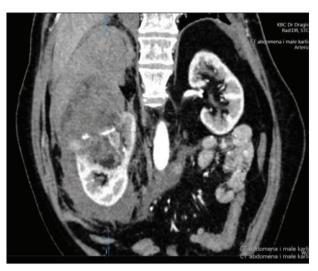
An intravenous-contrast-enhanced coronal computed tomography image shows perirenal hematoma of the right kidney and free fluid
